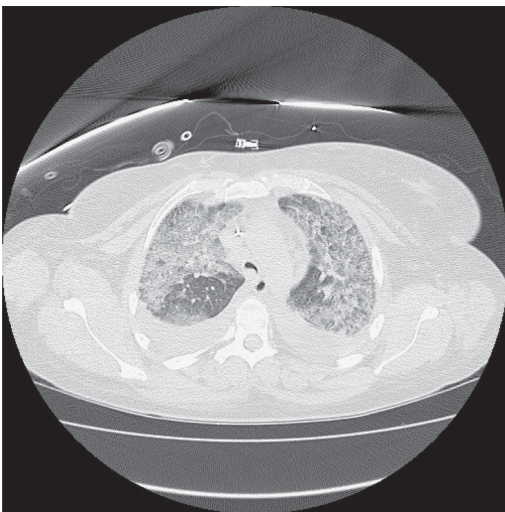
CT scan demonstrating diffuse bilateral infiltrates.
